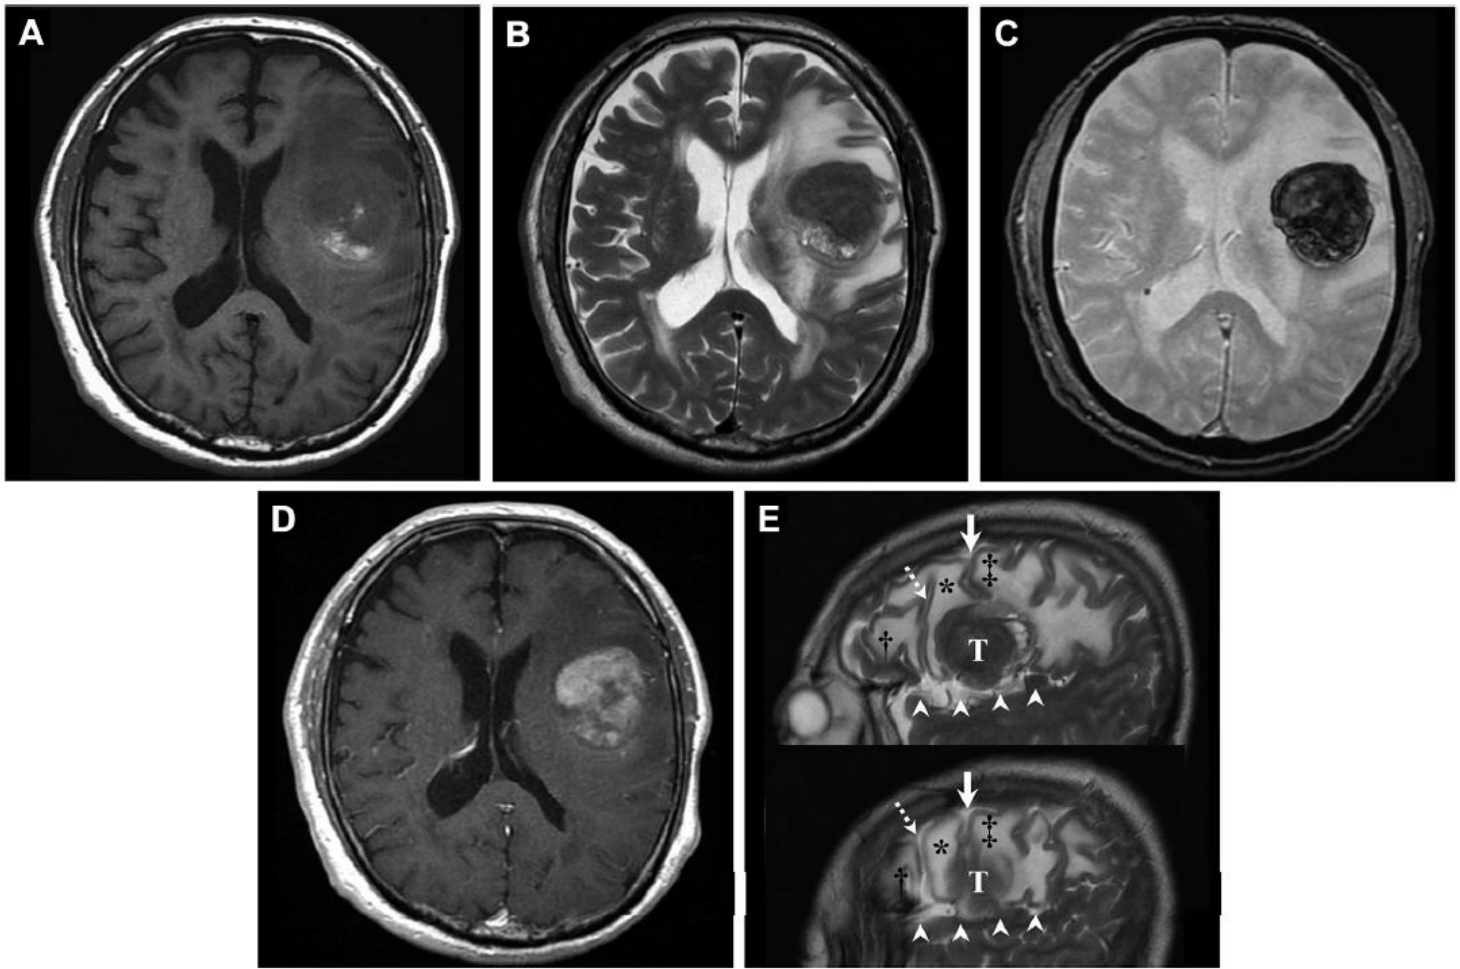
Magnetic resonance (MR) image shows (A) a round, isointense area with focal hyperintensity on axial T1-weighted imaging (T1WI); (B) a round, low-intensity area with focal hyperintensity on the axial T2-weighted imaging (T2WI); and (C) a well-demarcated, round, low-intensity area in the left frontal lobe on axial T2*-weighted imaging. (D) Axial T1WI with contrast medium shows a mass lesion with heterogeneous enhancement in the left
